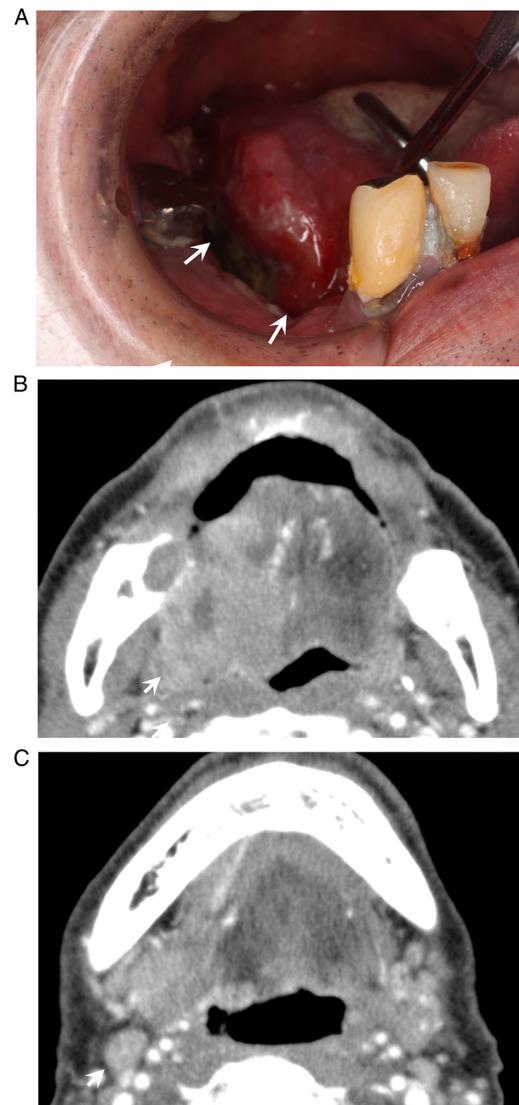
Representative clinical and imaging findings in Case 1. (A) Intraoperative photograph revealed an elastic and hard mass with a central ulceration involving the right tongue (white arrow). (B) Contrast-enhanced axial computed tomography showed a poorly marginated lesion (white arrow) and (C) right regional lymph node involvement (white arrow).
